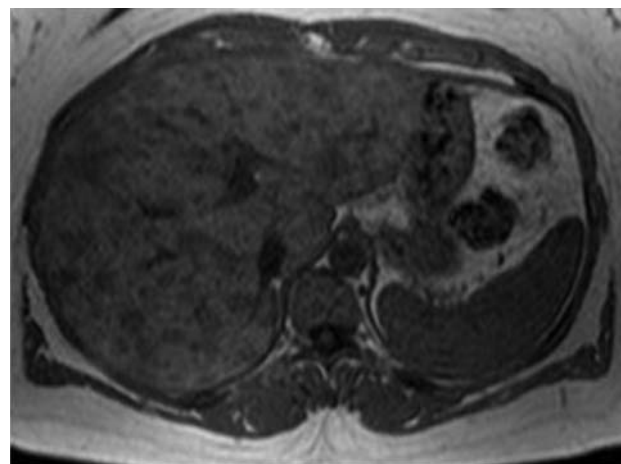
Abdominal magnetic resonance imaging in June 2005 (T1 without gadolinium injection) showing diffuse nodular infiltration of the liver.
